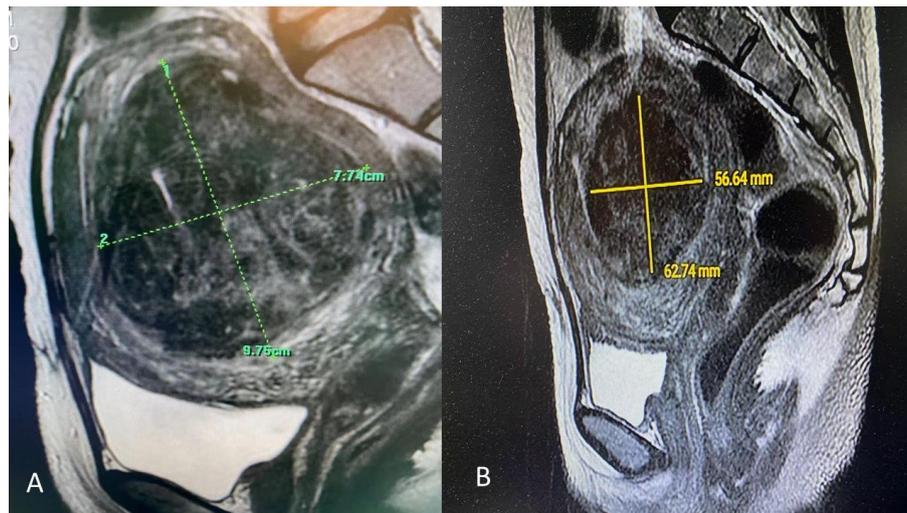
(A) MRI image of a recurrent fibroid before HIFU ablation in a young athlete. (B) MRI image of the fibroid at three months after HIFU ablation.
